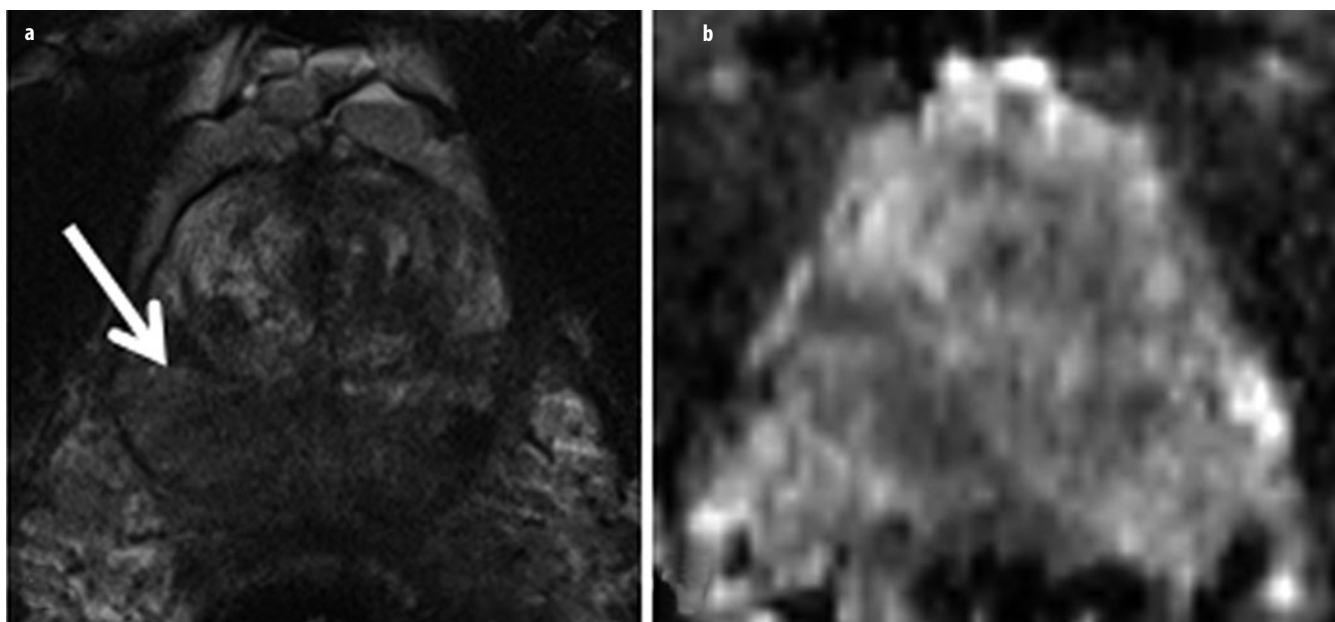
a, b. Granulomatous prostatitis. a Axial T2-weighted turbo-spin-echo (TSE) and b corresponding apparent diffusion coefficient (ADC) map of a patient with prostate-specific-antigen (PSA) values between 6-8 ng/ml and three transrectal ultrasound (US)-guided biopsies without detecting cancer. The extensive and partially significantly T2-weighted hypointense changes (*arrow*) were diagnosed as granulomatous prostatitis after targeted magnetic resonance imaging (MRI)-guided biopsy. The finding in T2-weighted imaging would also be consistent with imaging of an advanced, diffusely growing prostate cancer
